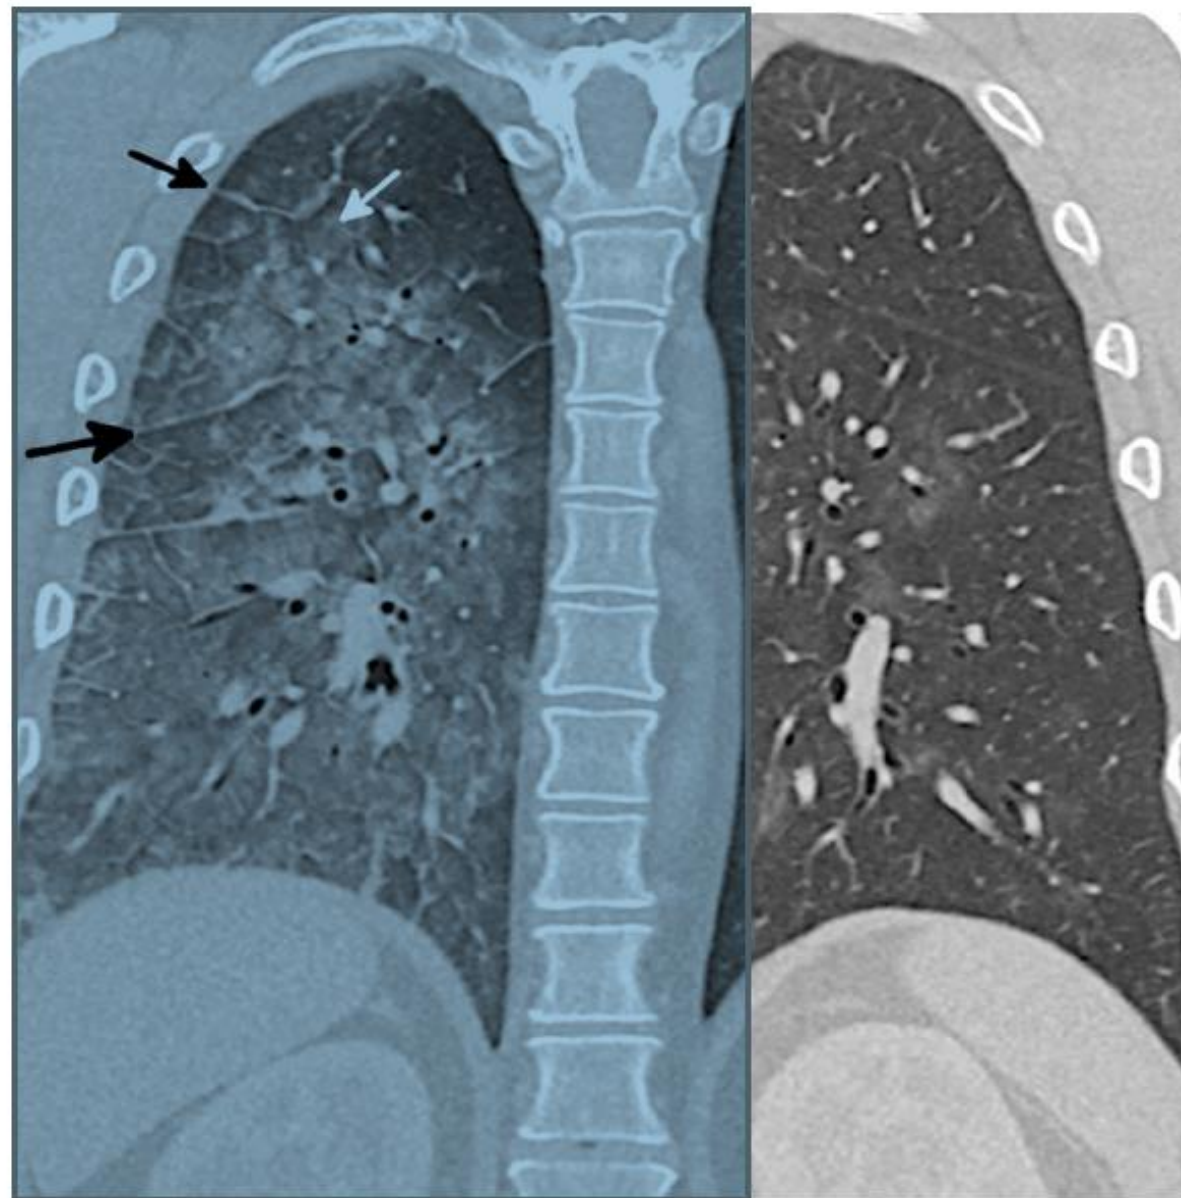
Diffuse alveolar hemorrhage (DAH) pattern in e-cigarette or vaping product use-associated lung injury. Coronal reformatted CT image of a 42-year-old man presenting with hemoptysis shows asymmetrical ground-glass opacity predominantly on the right with septal thickening (black arrows) and ill-defined ground-glass acinar nodules (white arrow) that fill most of the secondary lobule, a finding common in DAH. BAL confirmed the diagnosis, and the patient rapidly improved with steroids. DAH was the only pattern that was commonly asymmetrical.
